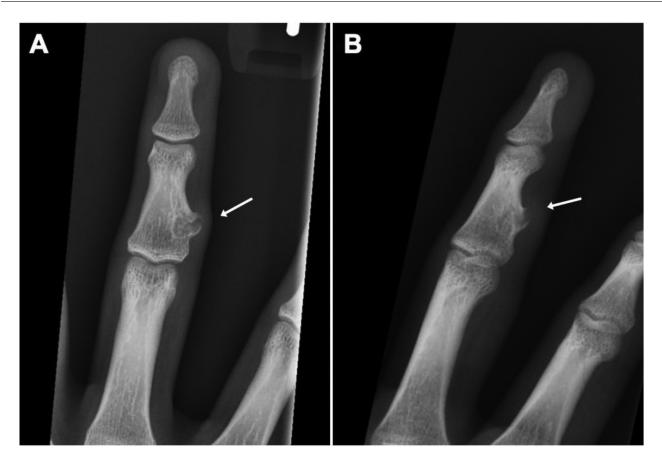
An 18-year-old male with a chronic mass of the left third finger. Frontal (A) and oblique (B) radiographs of the left third finger show a small well-circumscribed expansile lucent lesion in the proximal middle phalanx of the left third finger with mild overlying soft tissue swelling (arrows).
